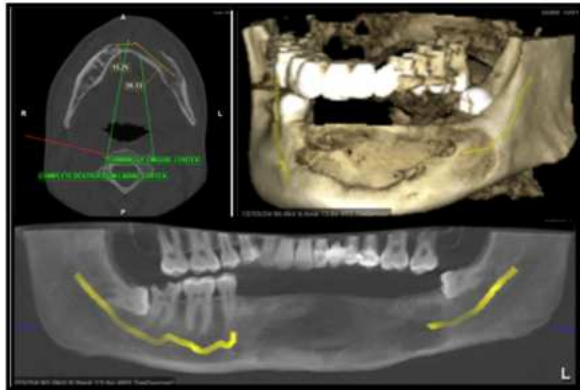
A: 6 Months follow up CBCT delineating successful postoperative bone regeneration
